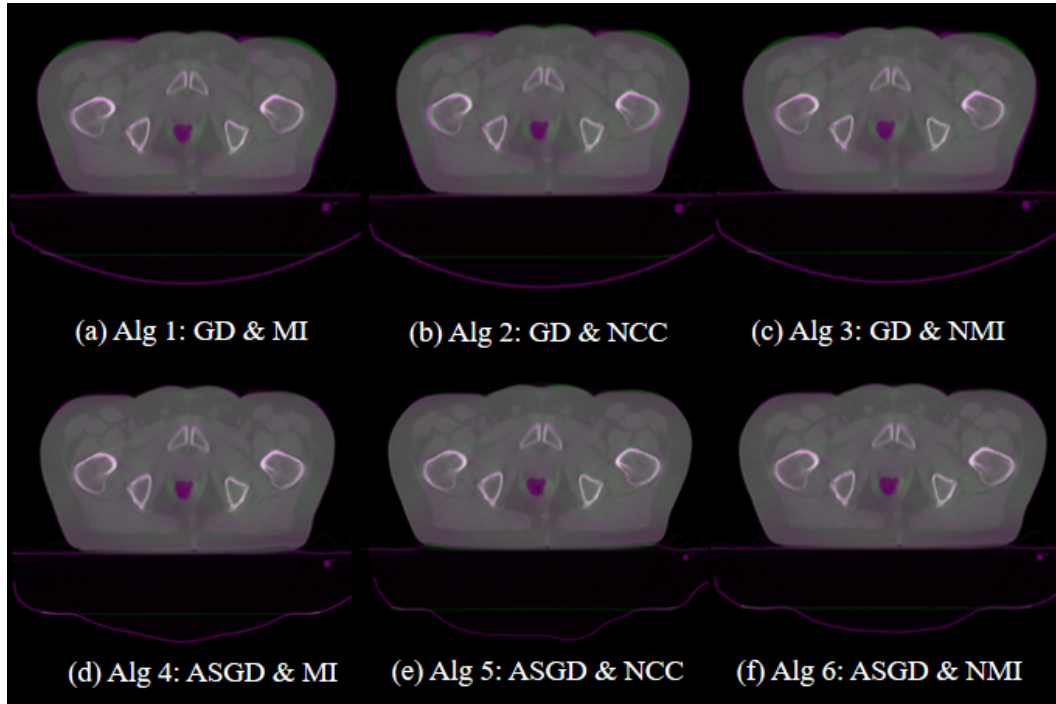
Results of superimposition of CBCT and deformed pCT images after using six DR algorithms based on (a) GD and MI (b) GD and NCC (c) GD and NMI (d) ASGD and MI (e) ASGD and NCC (f) ASGD and NMI.
